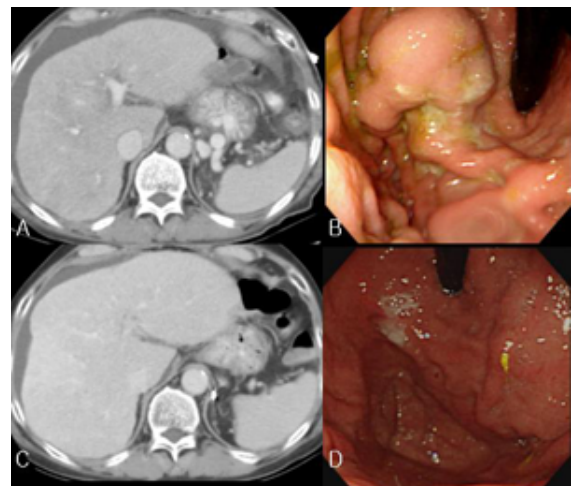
Both follow-up CT scan (C) and endoscopy (D) obtained 6 months after BRTD reveals no recurrence of the gastric varix. (A), (B) = before BRTD.
